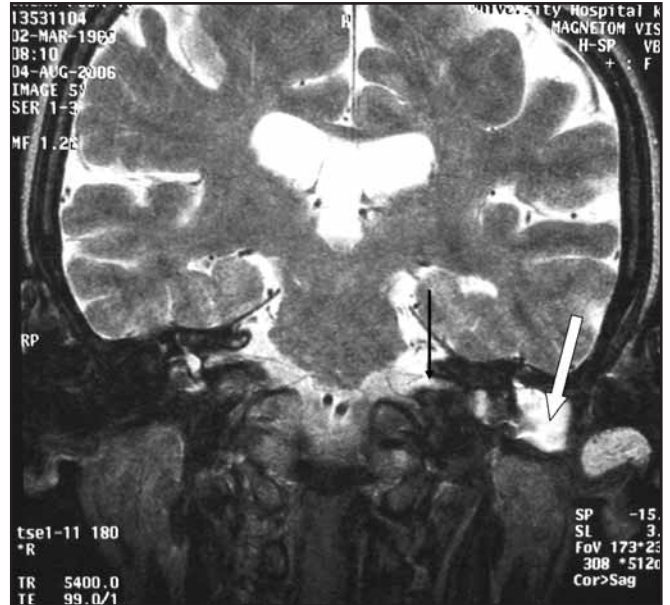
T2 weighted MRI scan (Coronal View) showing CSF leak from the left internal auditory meatus (black arrow) into the left middle-ear (white arrow)
